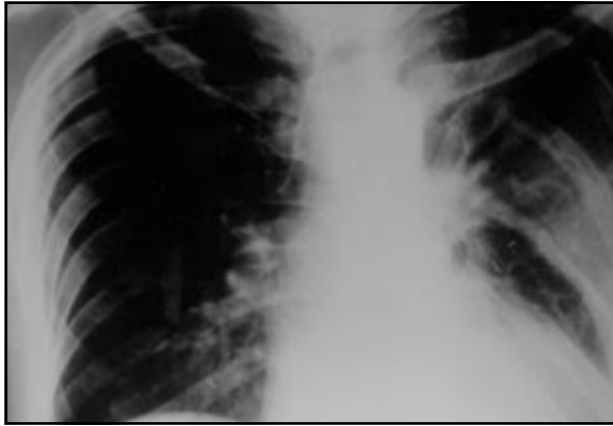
A post-operative plain X-ray with a follow-up in 10 years after surgery without tumor.
